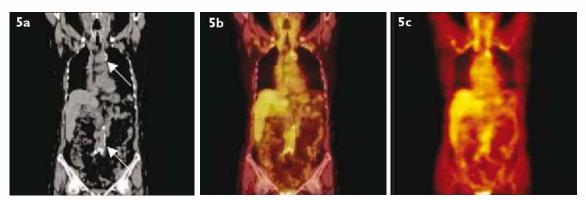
(a) Reconstructed MPR coronal CT image of the thorax and abdomen shows multifocal calcifications along the wall of arch and abdominal aorta (white arrow). (b) Fused and (c) PET images show that the high uptake of 18F-FDG along the upper thoracic and lower abdominal vessels is as intense as, or more intense than, the liver activity.
